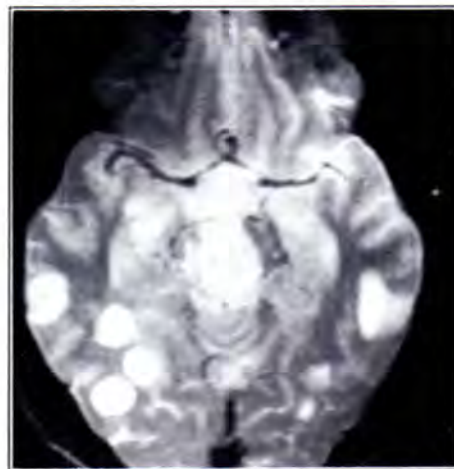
Toxoplasmosis. This T2-weighted MR image is that of a 33 year old AIDS patient. A large rounded mass lesion is identified in the midbrain (center) and several smaller rounded mass lesions are seen in the temporal lobes bilaterally.
